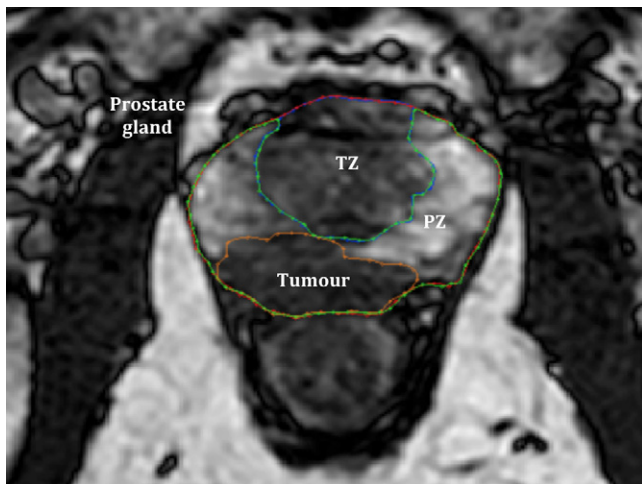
T1W axial MR image of prostate with delineation of prostate gland, peripheral zone (PZ), transition zone (TZ) and tumour in the peripheral zone.
